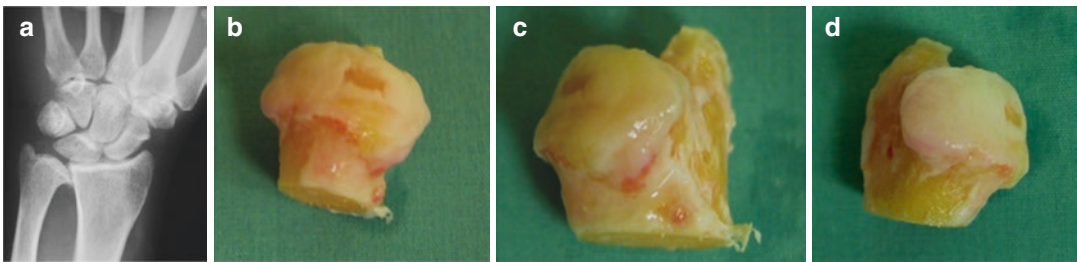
Radiograph shows joint space narrowing, osteophytes, and sclerosis consistent with DRUJ arthritis. Clinical photographs show eburnation of cartilage and osteophytes of the ulnar head
